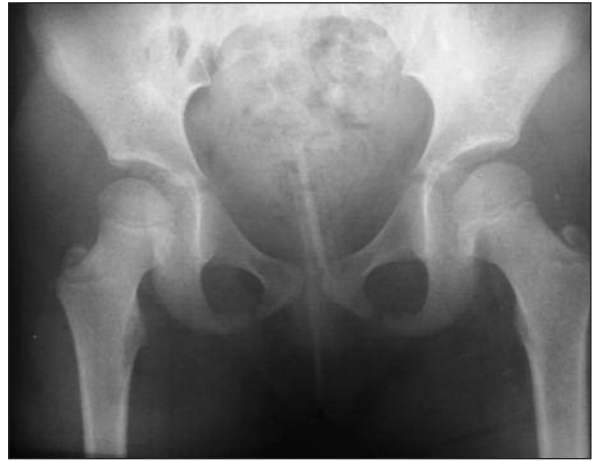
X-ray of pelvis showing a thin and long dense image in pelvic region.
